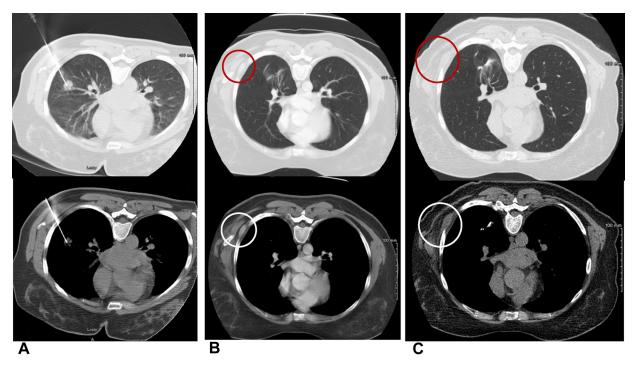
A-C, Percutaneous transthoracic needle biopsy and comparison scans showing location of new chest wall mass. A, Initial diagnosis; B, 44 months following resection; and C, 48 months following resection.
